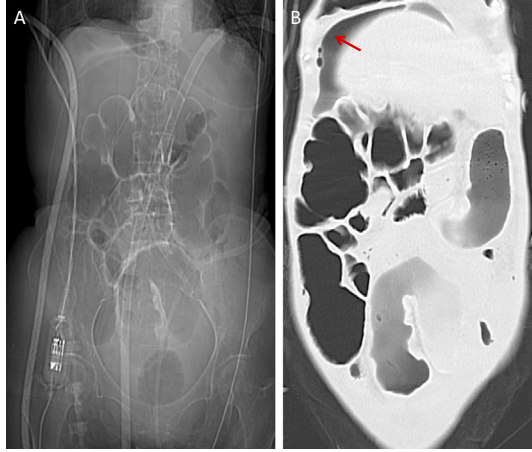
Abdominal radiography and computed tomography findings. Radiograph (A) and computed tomography scan (B) showing the entire colon filled with gas and free air in the suprahepatic area (red arrow).
